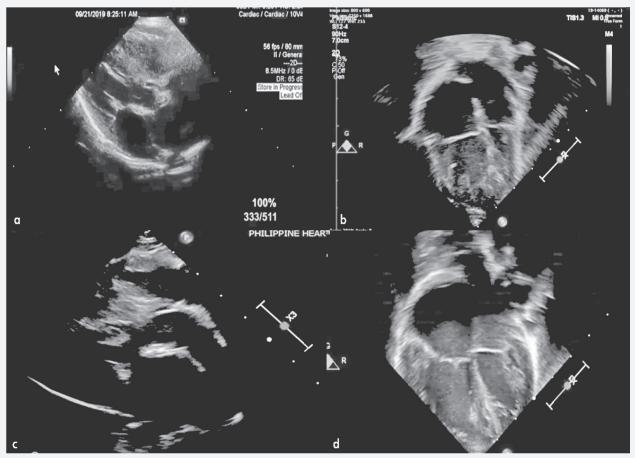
Echocardiographic views of the left ventricle showing comparable left ventricular wall thickness and volume before ductal stenting (A, B) and after 6 weeks of LV retraining (C, D)
